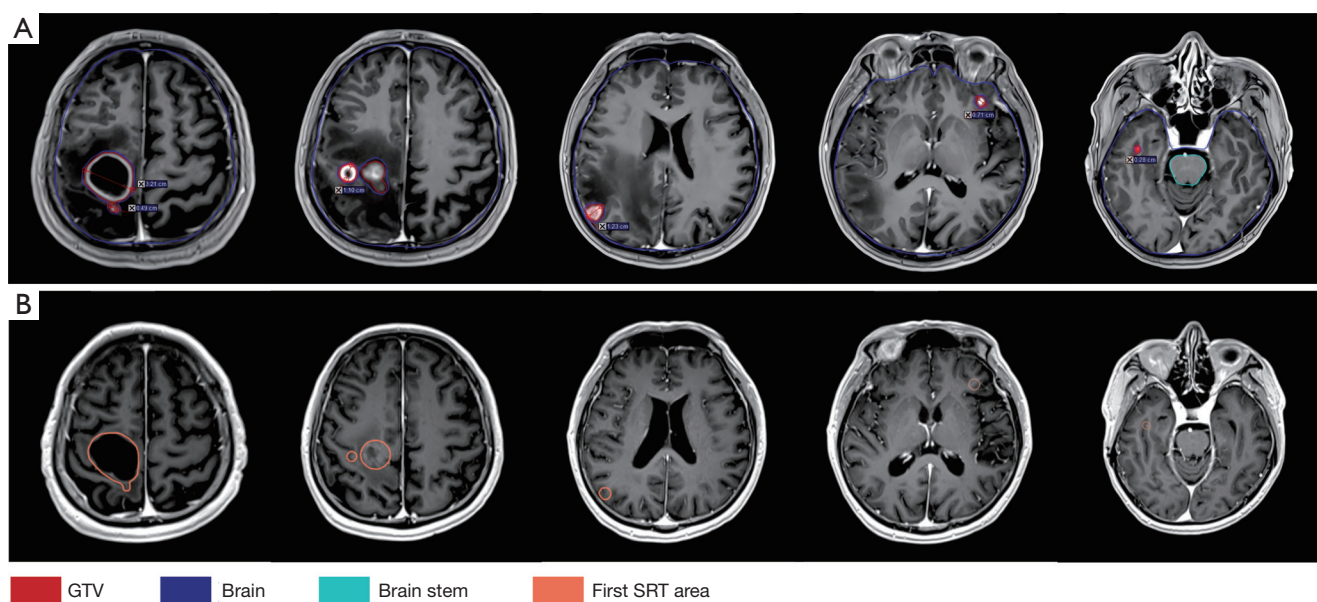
The changes in the initial 6 intracranial lesions and areas involved. (A) The location of the GTV and OARs for the first SRT from positioning MRI performed on September 15, 2022. (B) Positioning MRI that was performed on February 10, 2023 for the second SRT; the orange areas were the positions where the lesions were located during the first SRT course and were delineated to avoid reirradiation. GTV, gross tumor volume; SRT, stereotactic radiotherapy; OARs, organs at risk; MRI, magnetic resonance imaging.
